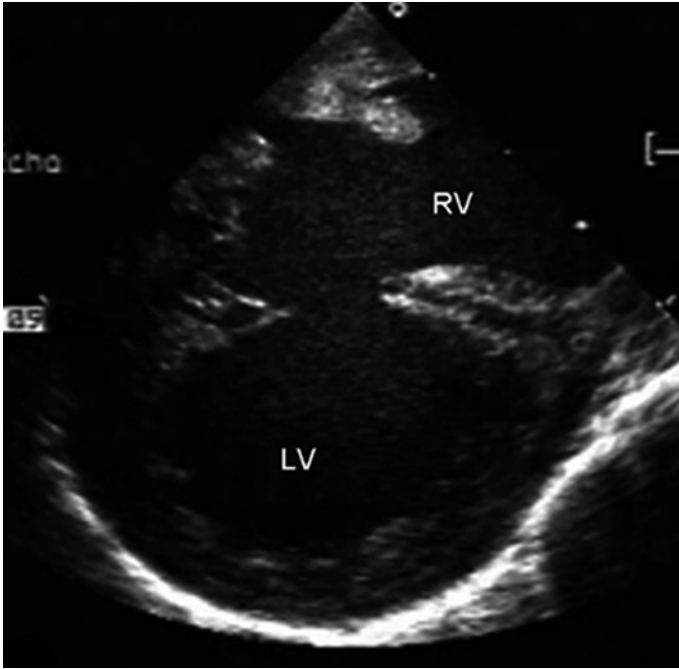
A large mid-muscular VSD delineated with epicardial echocardiography in a 4.8 kg patient. Epicardial echo can be useful as the probe can be used to mimic the desired angle and direction for the wire and sheath passage. *RV* right ventricle, *LV* left ventricle
